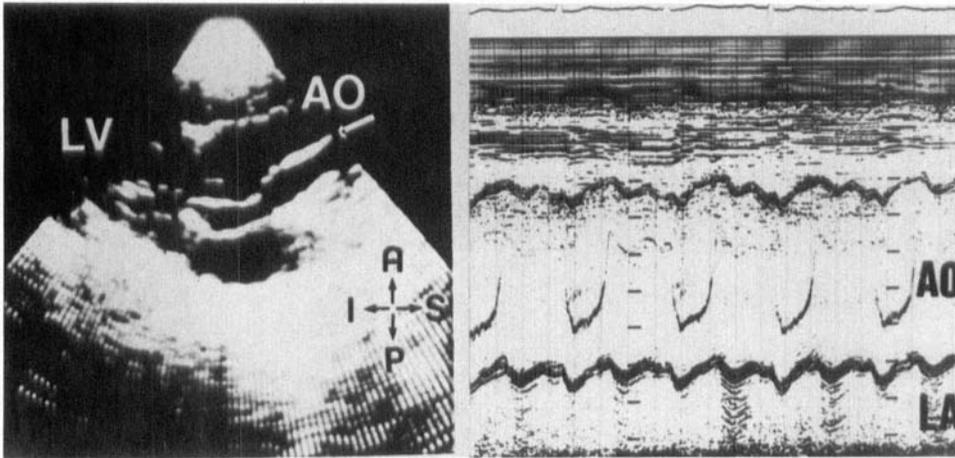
First typical aspect of aortic dissection with an "oscillating flap." On parasternal long-axis view, we can visualize the two main criteria of aortic dissection: (1) The dilation of the aorta and (2) the abnormal linear image in the lumen; the simultaneous M-mode recording shows the very suggestive "sail-like" motion of the intimal flap. Ao: aorta. LA: left atrium, LV: left ventricle, A: anterior, P: posterior, I: inferior, S: superior.
